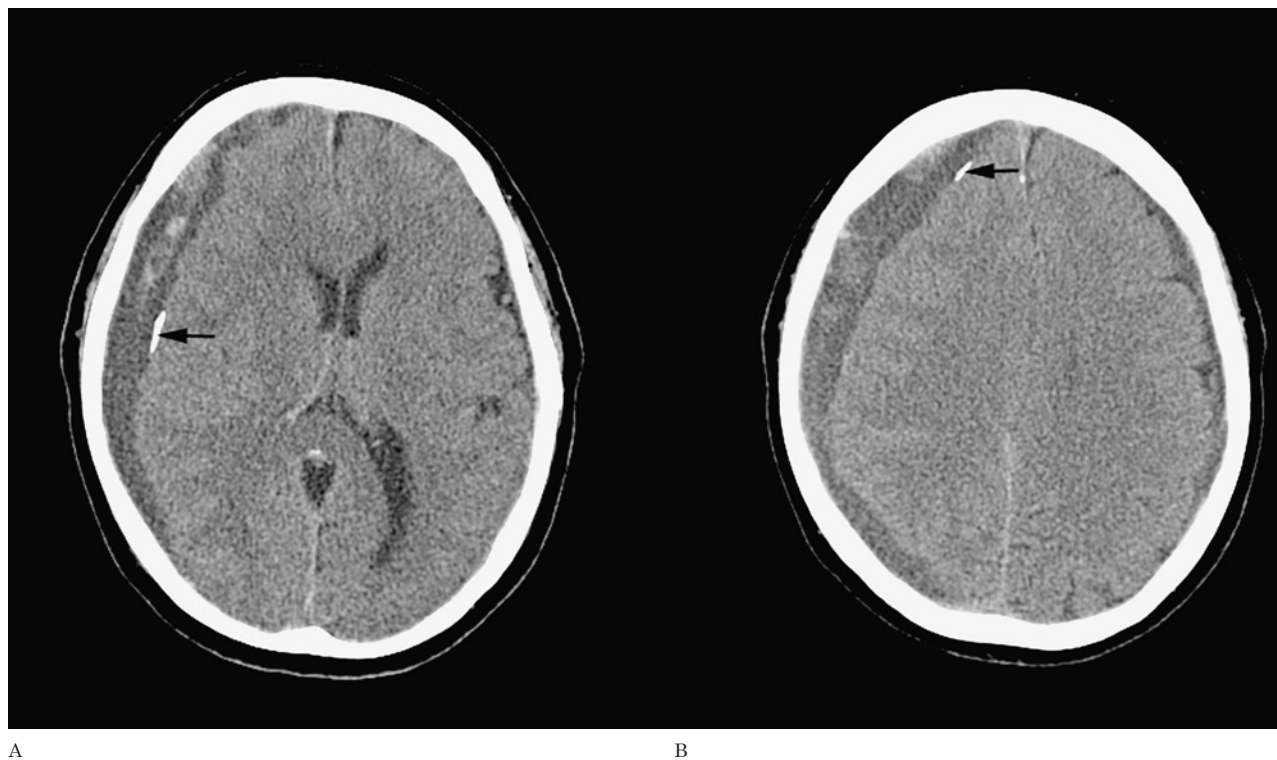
Subdural haematoma. A, B) Axial nonenhanced CT images show acute on chronic right, subdural haematoma with calcifications (arrows) along the inner surface.
